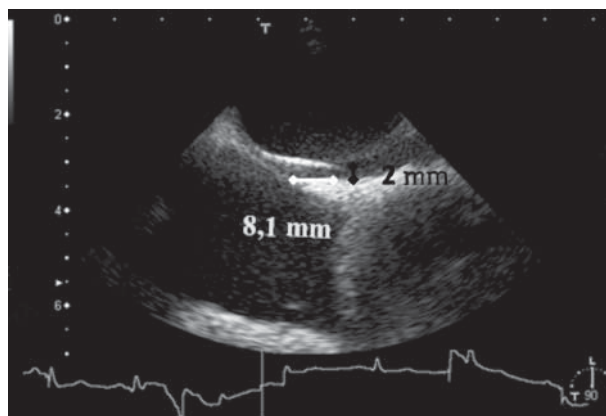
Transoesophageal echocardiography. Longitudinal biatrial/bicaval view. Measurement of PFO channel length — overlap of the septum primum and secundum (white) is 8.1 mm. Measurement of PFO separation — distance between the septum primum and secundum (black) is 3.8 mm
